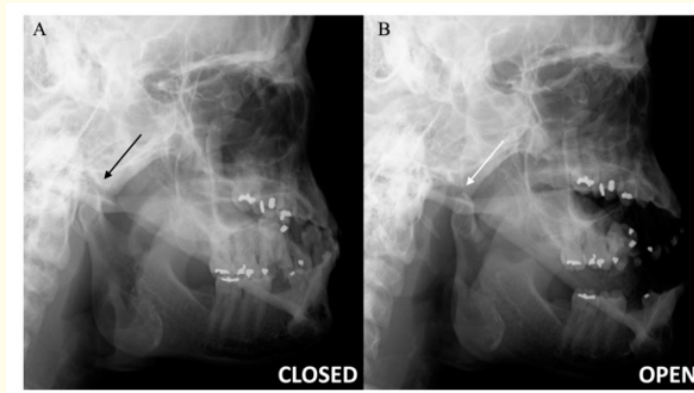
TMJD - 2D x-ray mouth view- open and closed.
